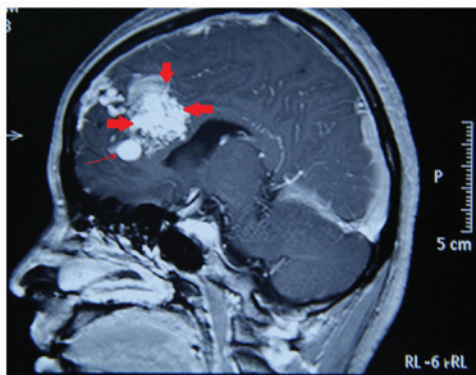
Preoperative magnetic resonance imaging demonstrated an arteriovenous malformation (thick red arrows) and associated aneurysm (thin red arrow).
